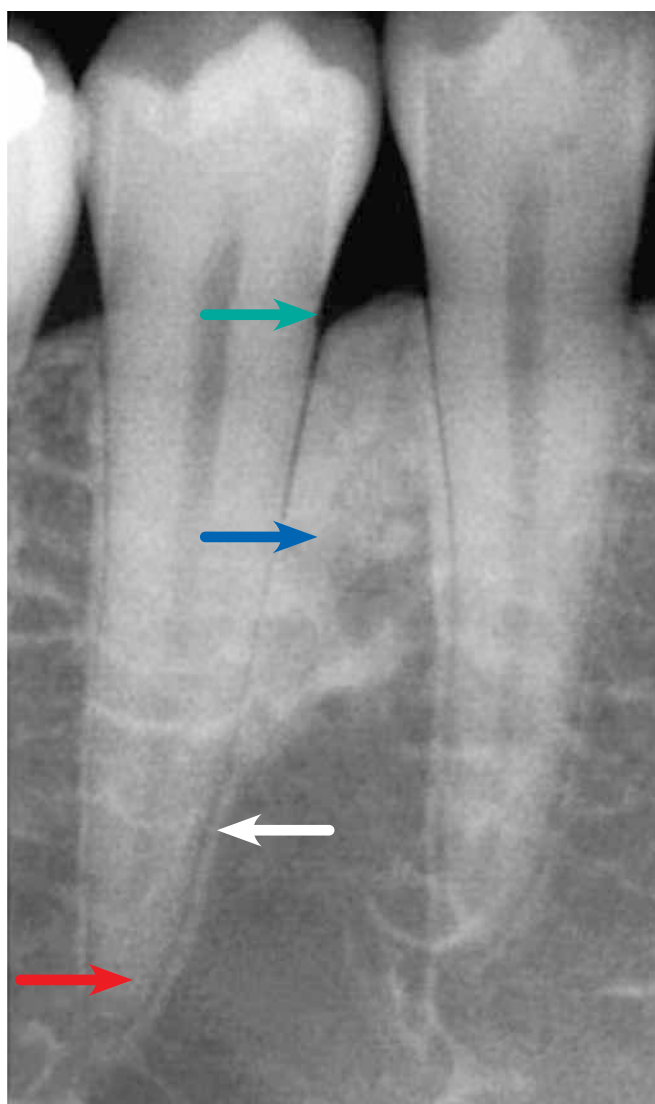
Occlusal Trauma with thickening of the lamina dura (white arrow), widening of the periodontal space (red arrows) with increased periapical periodontal bone density (blue arrow), and V-shaped vertical bone loss (green arrow).
